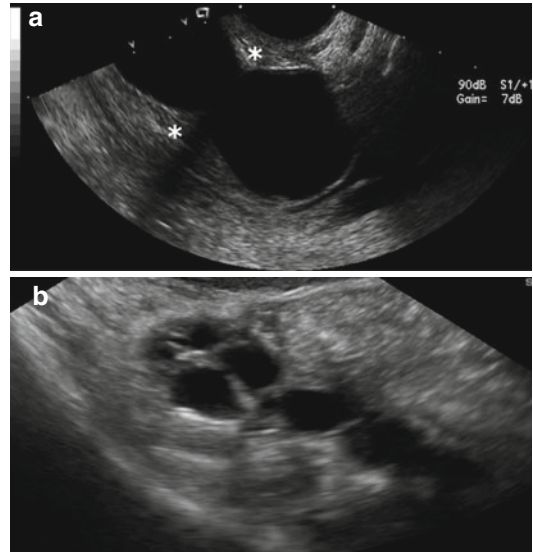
(a) “Waist sign” of a hydrosalpinx, marked by the asterisks, as seen with 2-D ultrasound. (b) “Beads on a string” sign of a hydrosalpinx demonstrated by 2-D ultrasound
